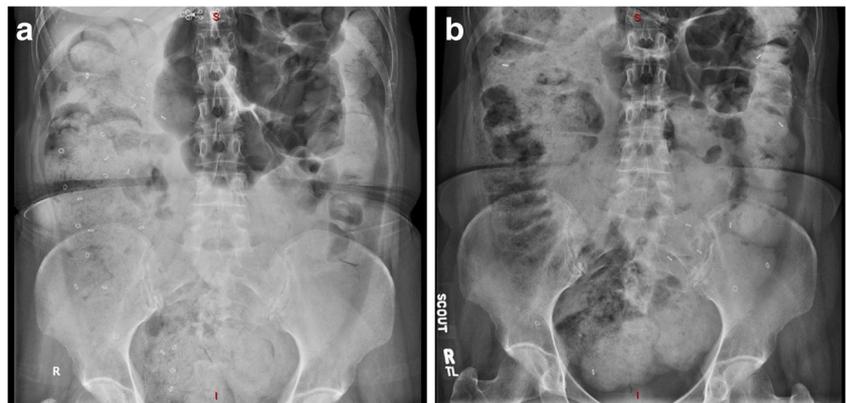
Computed tomography of abdomen and pelvis with and without contrast showing marked colonic distension filled with feces. There is no evidence of a volvulus or a sigmoid mass. Distal sigmoid and rectum are completely collapsed
